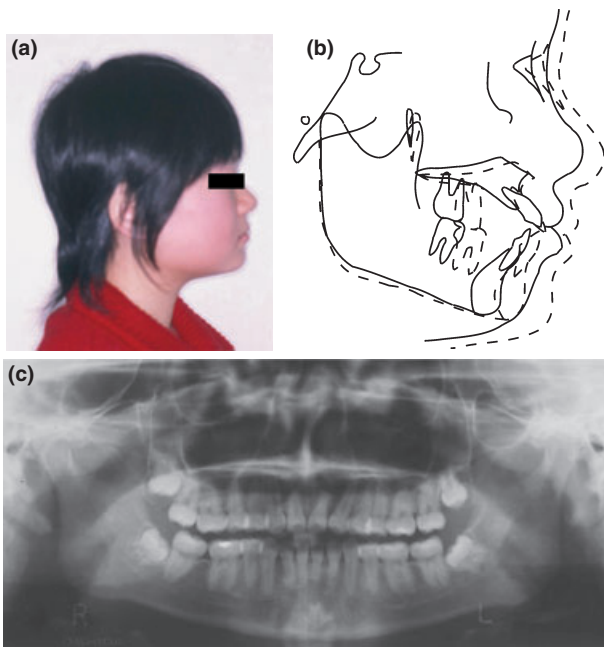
(a) Posttreatment facial photograph. (b) Cephalometric superimpose. Solid line pretreatment; dotted line posttreatment. (c) Panoramic radiograph obtained after treatment.
